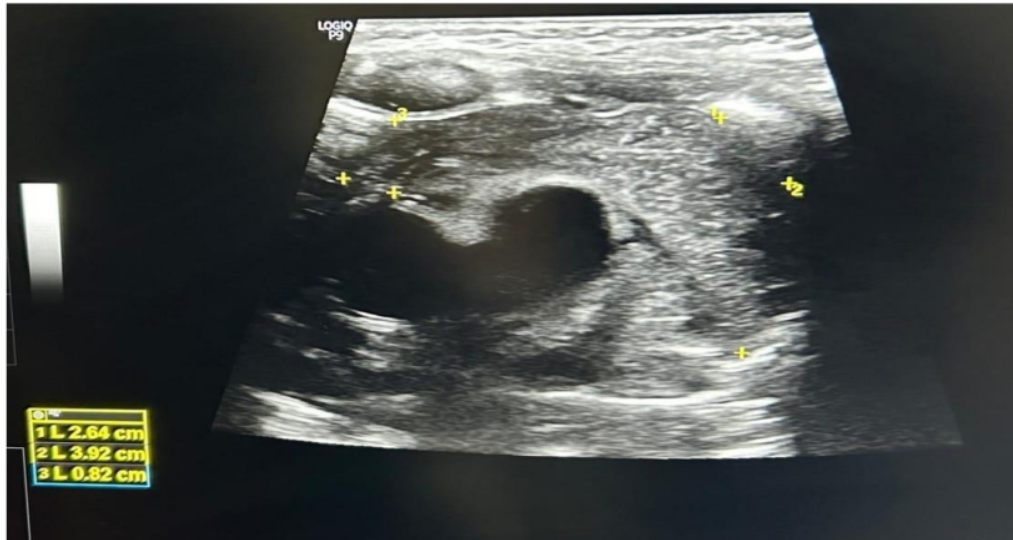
shows ultrasonographic measurement of thymic area
